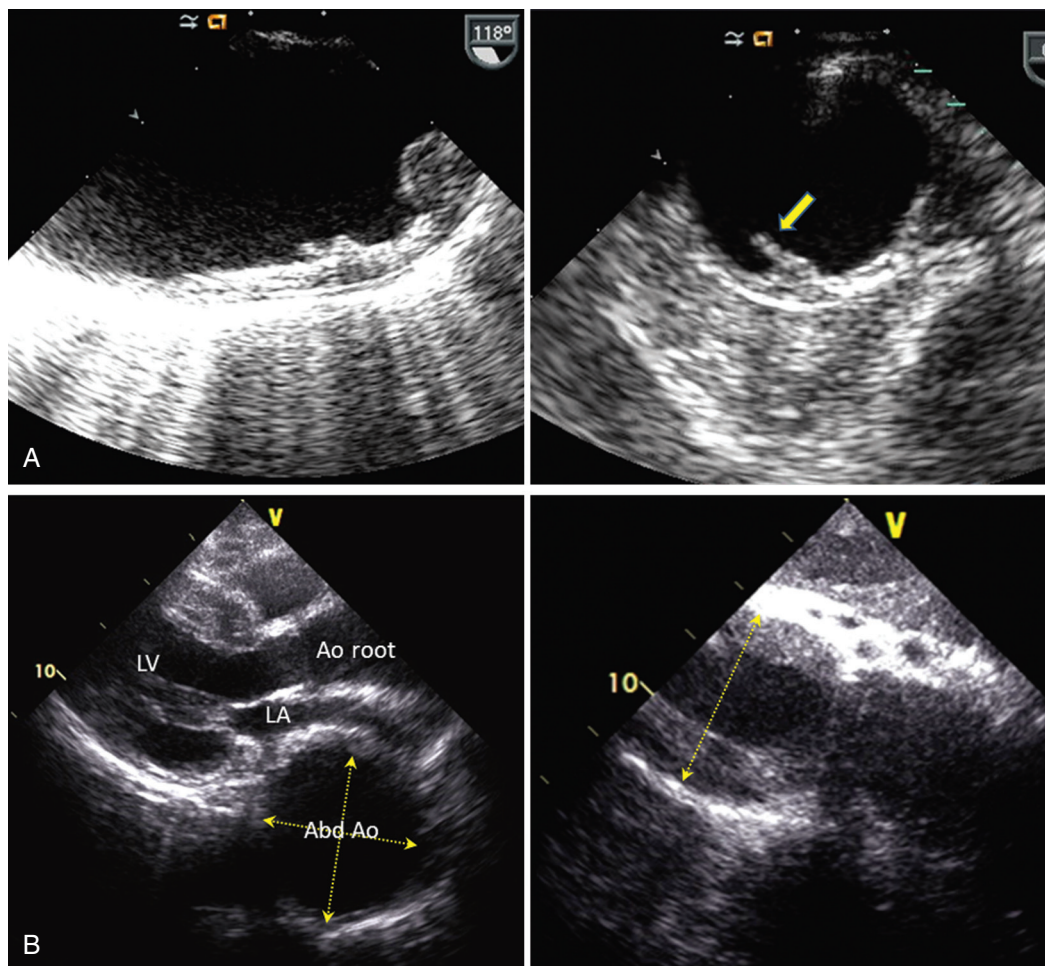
Aortic atheroma and aneurysm. A, Transesophageal views of complex aortic atheroma in the ascending aorta. In the long-axis view (*left panel*), the atheroma is seen to be irregular and measures up to 1.0 cm in thickness. In the short-axis view (*right panel*), protuberant finger-like atheroma is seen and is independently mobile. B, Transthoracic parasternal long-axis (*left*) and subcostal (*right*) views of a large 7-cm-diameter descending thoracoabdominal aortic aneurysm (*dotted arrows* spanning the diameter) compressing the posterior aspect of the left atrium (LA), with diffuse circumferential thick mural thrombus layered within the endocardial borders. Ao root = aortic root; LV = left ventricle.
